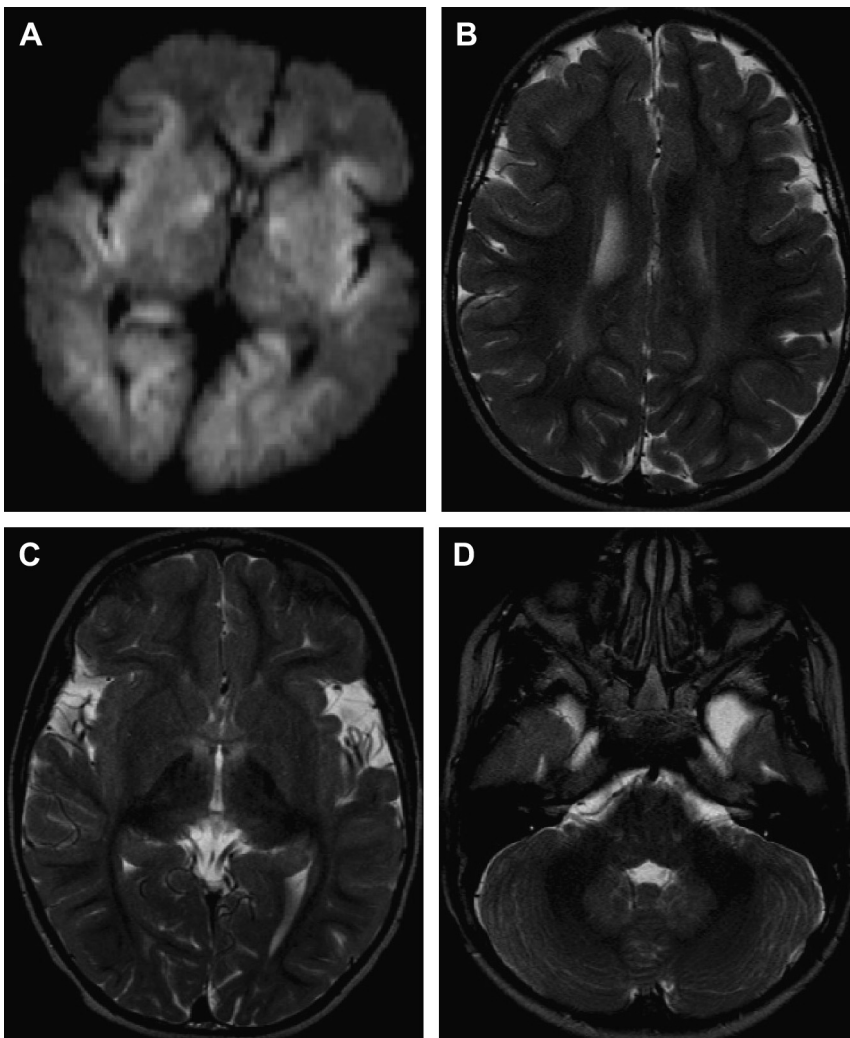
Gray and white matter involvement in urea cycle and mitochondrial disorders. Six-day-old boy with ornithine transcarbamylase deficiency and seizure: diffusion-weighted image (A) demonstrates insular cortex and globus pallidus signal abnormality as well as areas of subcortical white matter hyperintensity. Three-year-old child with glutaric aciduria type I: axial T2-weighted images (B–D) demonstrate periventricular, basal ganglia, and dentate signal abnormality as well as the characteristic opercular widening seen in this disorder.
